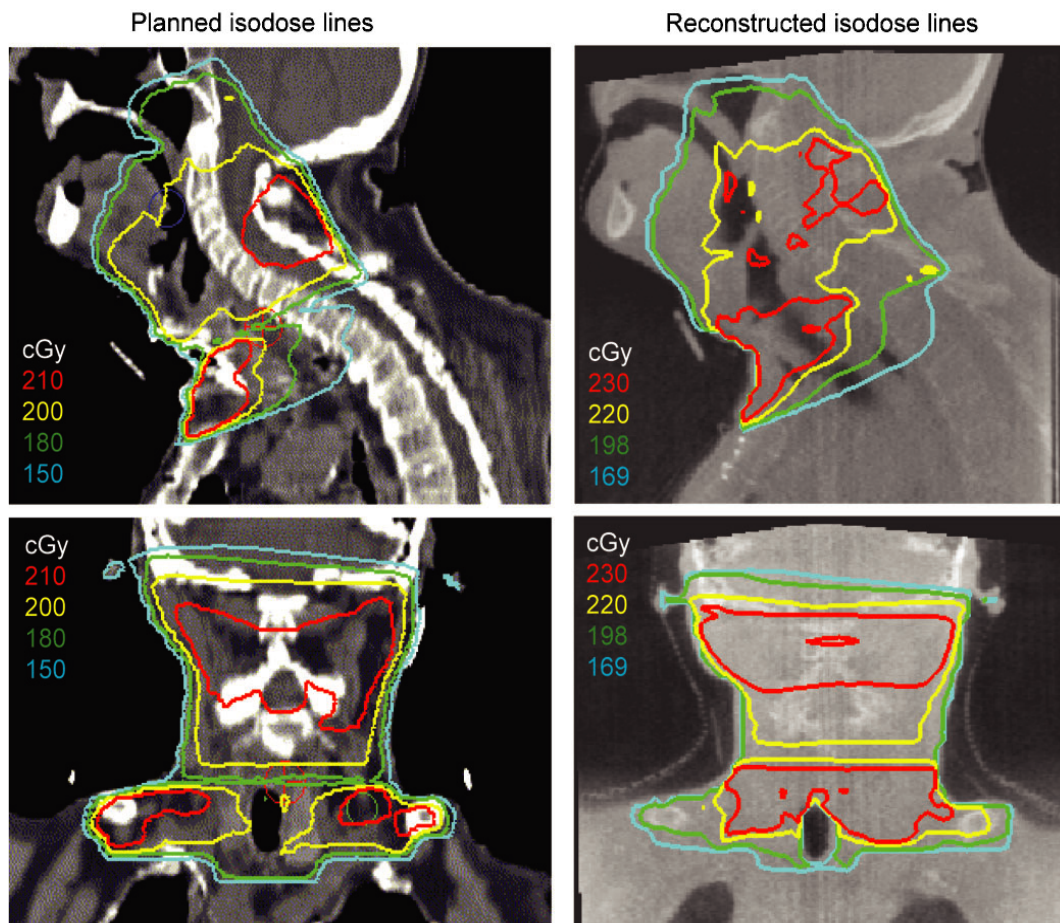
Comparisons between planned isodose contours calculated using the patient kV CT image and a commercial treatment planning system (left) and reconstructed isodose contours calculated using the megavoltage cone beam CT (MV CBCT), the treatment-time portal images, and an in-house dose reconstruction program (right).
